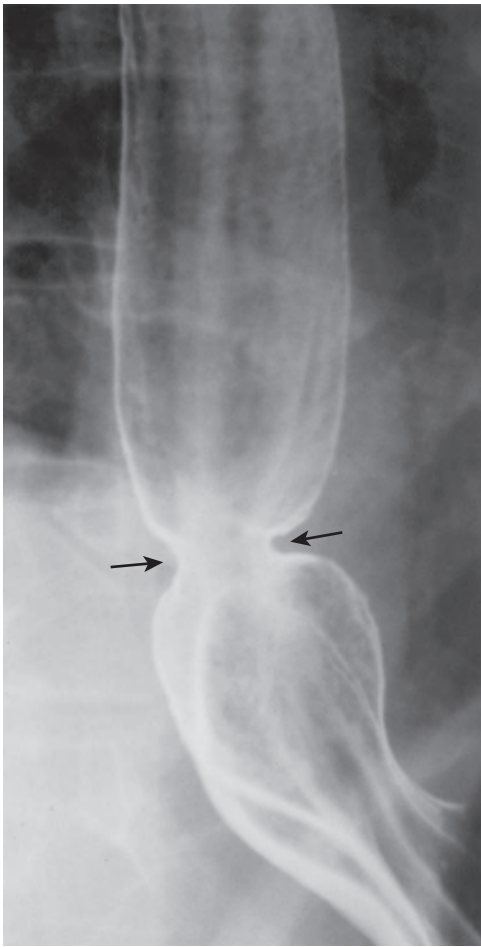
Ringlike peptic stricture. There is a ringlike stricture (arrows) in the distal esophagus above a hiatal hernia. Although this stricture could be mistaken for a Schatzki ring, it has a longer vertical height and more tapered margins than a true Schatzki ring. (From Luedtke P, Levine MS, Rubesin SE, et al: *Radiologic diagnosis of benign esophageal strictures: A pattern approach*. RadioGraphics 23:897–909, 2003.)
